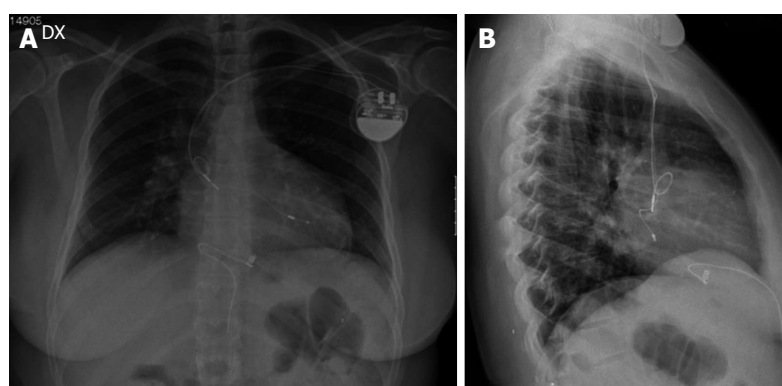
Chest X-ray. A: Antero-posterior chest X-ray after pacemaker implantation to confirm the position of the pacemaker leads. The ventricular lead is situated in the anatomic left ventricle, and the atrial lead in the systemic venous baffle; B: Lateral chest X-ray after pacemaker implantation to confirm the position of the pacemaker leads. In this patient the left atrial appendage was kept outside of venous tissue therefore the atrial lead was inserted and screwed into the systemic venous channel and a loop was created.
